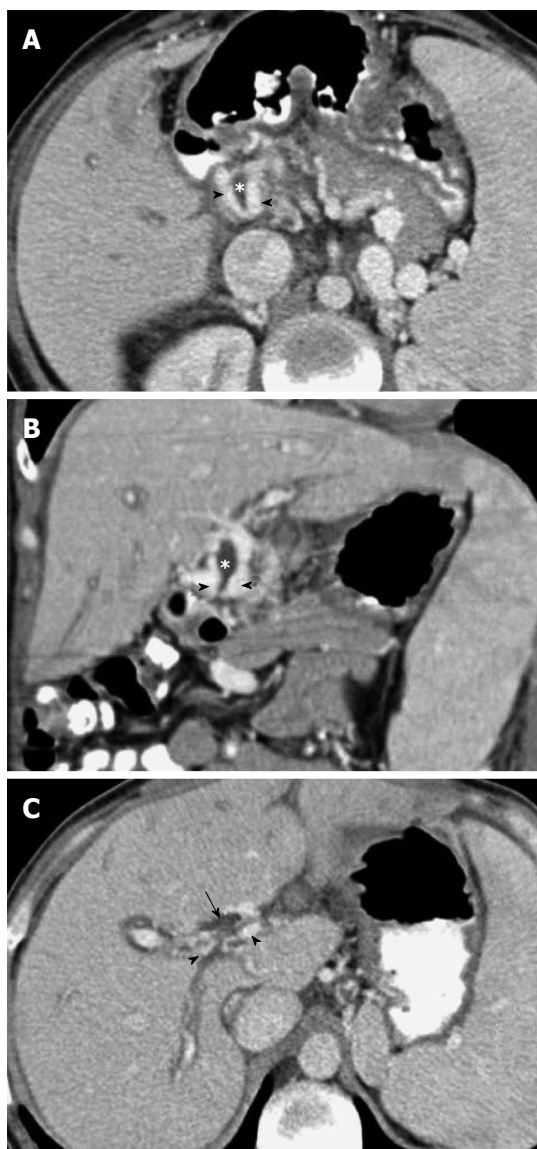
Portal phase abdominal computed tomography. A, B: Axial (A) and coronal planes (B) show multiple dilated collateral representing the para-choledochal plexus (arrowheads) with reduced diameter of the bile duct (*), secondary to extrinsic compression by the cavernoma; C: The superior axial image shows dilatation of the bile ducts (arrow).
